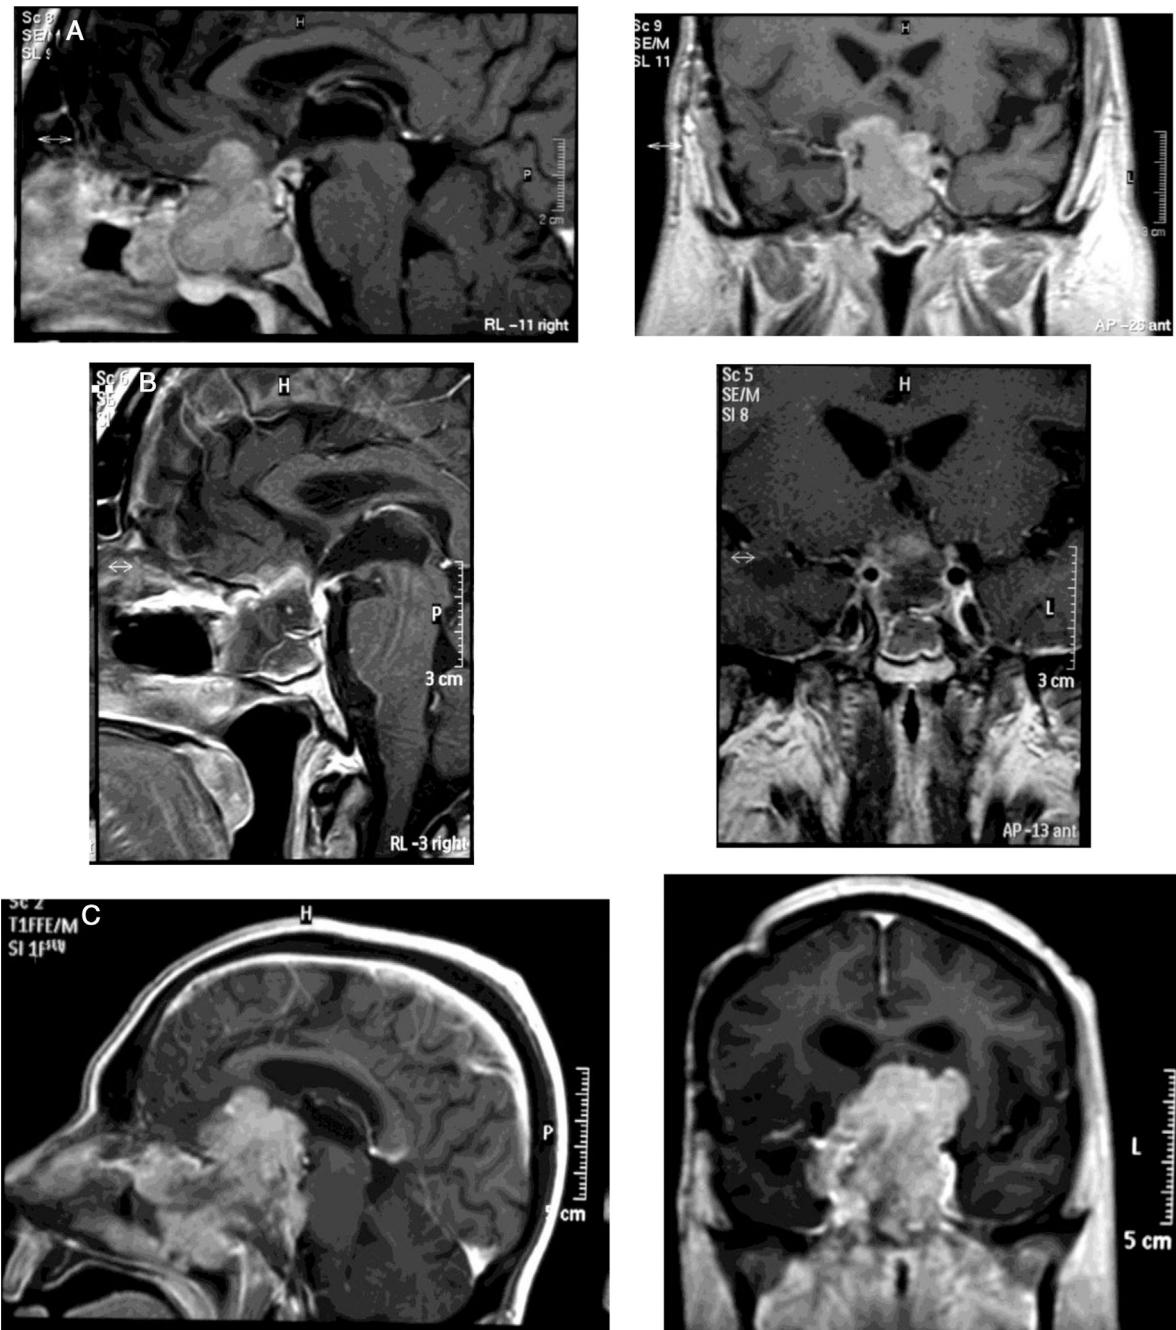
Sagittal and coronal pituitary T1-weighted MRI images of an aggressive type 2 silent corticotroph adenoma (sparsely granulated tumor) at different times of the disease. A. Before second surgery. B. After second surgery. C. Four months after second surgery.
